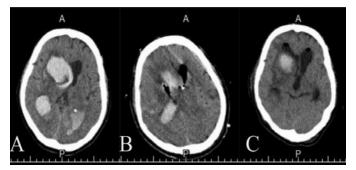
A shows the ictal CT scan of Patient B. B shows the postrtPA scan with misplacement and pneumocephalus. C shows the end-of-treatment and post-EVD removal CT.
